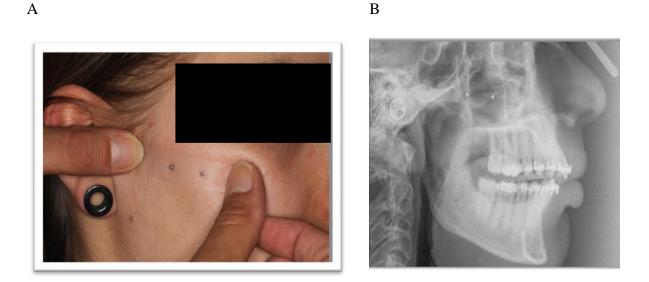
Use of radioopaque skin markers. A. placement of the markers. B. markers visible in radiograph (courtesy of LKH Feldkirch)
